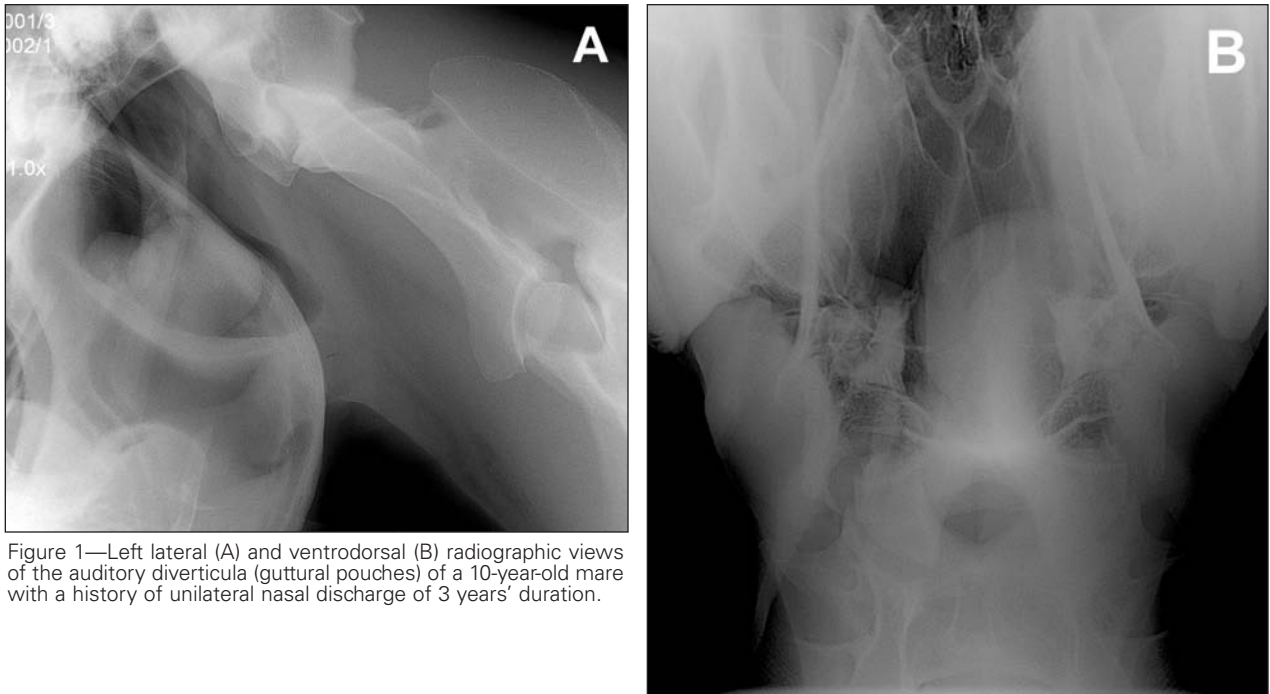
Left lateral (A) and ventrodorsal (B) radiographic views of the auditory diverticula (guttural pouches) of a 10-year-old mare with a history of unilateral nasal discharge of 3 years' duration.
